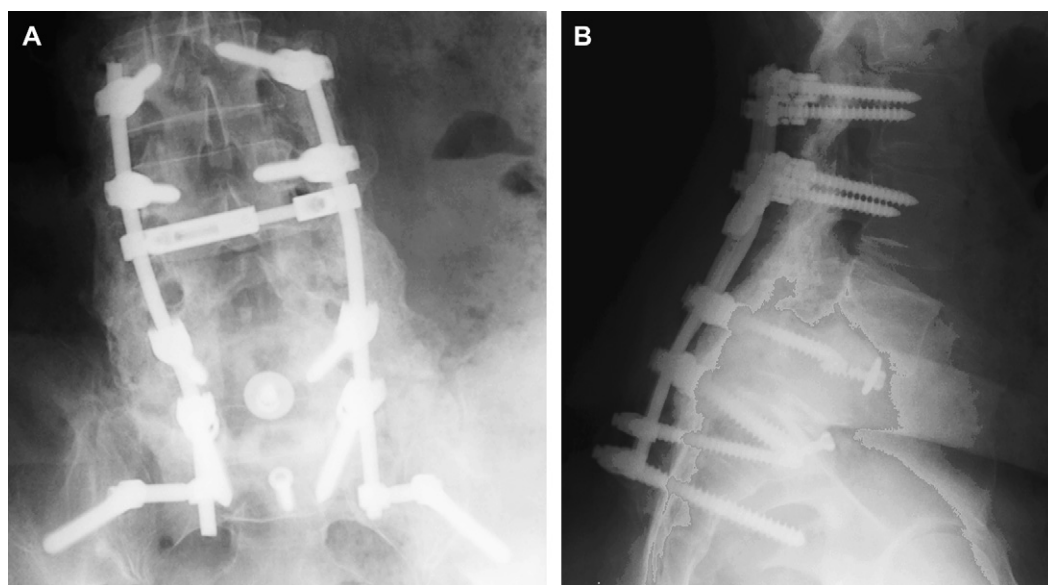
A 50-year-old patient 14 months after L2-ilium revision posterior spinal fusion (rhBMP-2, 40 mg per level, with CRM) for L4-L5 and L5-S1 pseudarthroses after index L4-S1 anteroposterior spinal fusion (for postlaminectomy spondylolisthesis). Standing long-cassette coronal (A) and lateral (B) radiographs at 14 months after surgery show an impressive posterior fusion mass from L2 to the sacrum. (From Luhmann SJ, Bridwell KH, Cheng I, et al. Use of bone morphogenetic protein-2 for adult spinal deformity. *Spine* 2005;30(17 Suppl):S113; with permission.)
